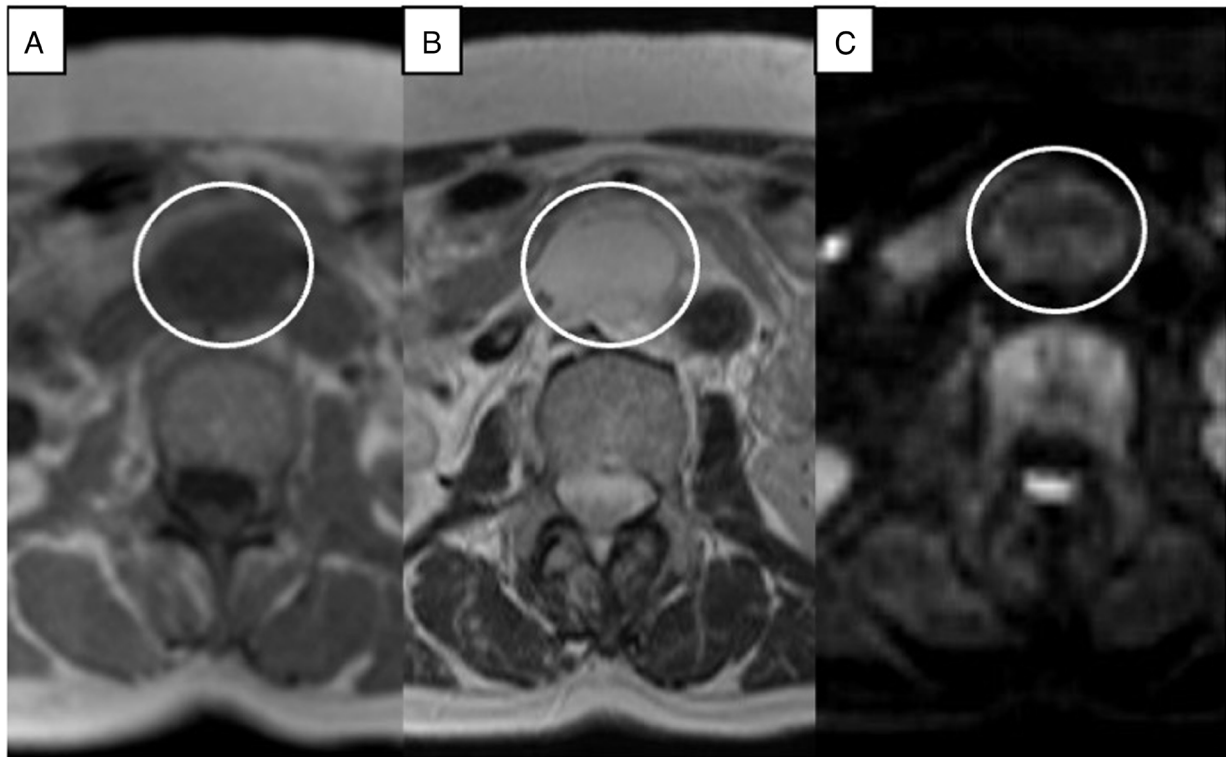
Abdominal MRI scan after 4 years. The white circle indicates the retroperitoneal tumor. Well-defined (A) T1-hypointense and (B) T2-hyperintense area. (C) Iso-density area on diffusion-weighted imaging.
